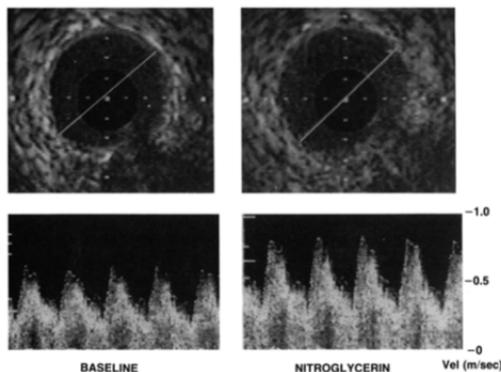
Two-dimensional ultrasound images (top panels) showing cross sections of the left circumflex coronary artery and spectral display (bottom panels) showing simultaneous Doppler velocimetry in the same coronary artery at baseline (left) and 2 min after administration of 200 μ g of intracoronary nitroglycerin (right).
